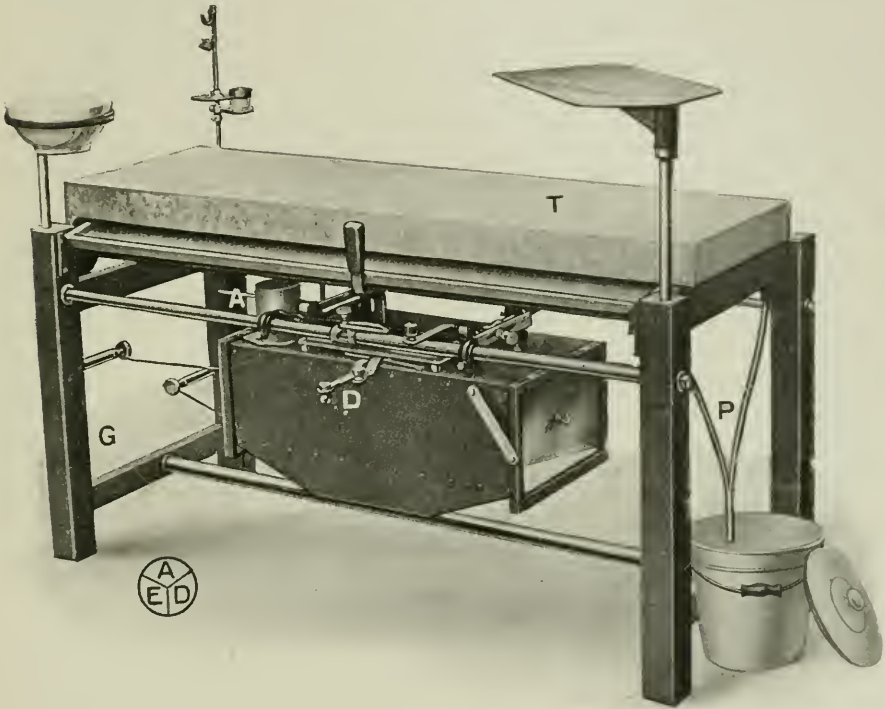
Atlas X-ray and operating table. (A. E. Dean.)
